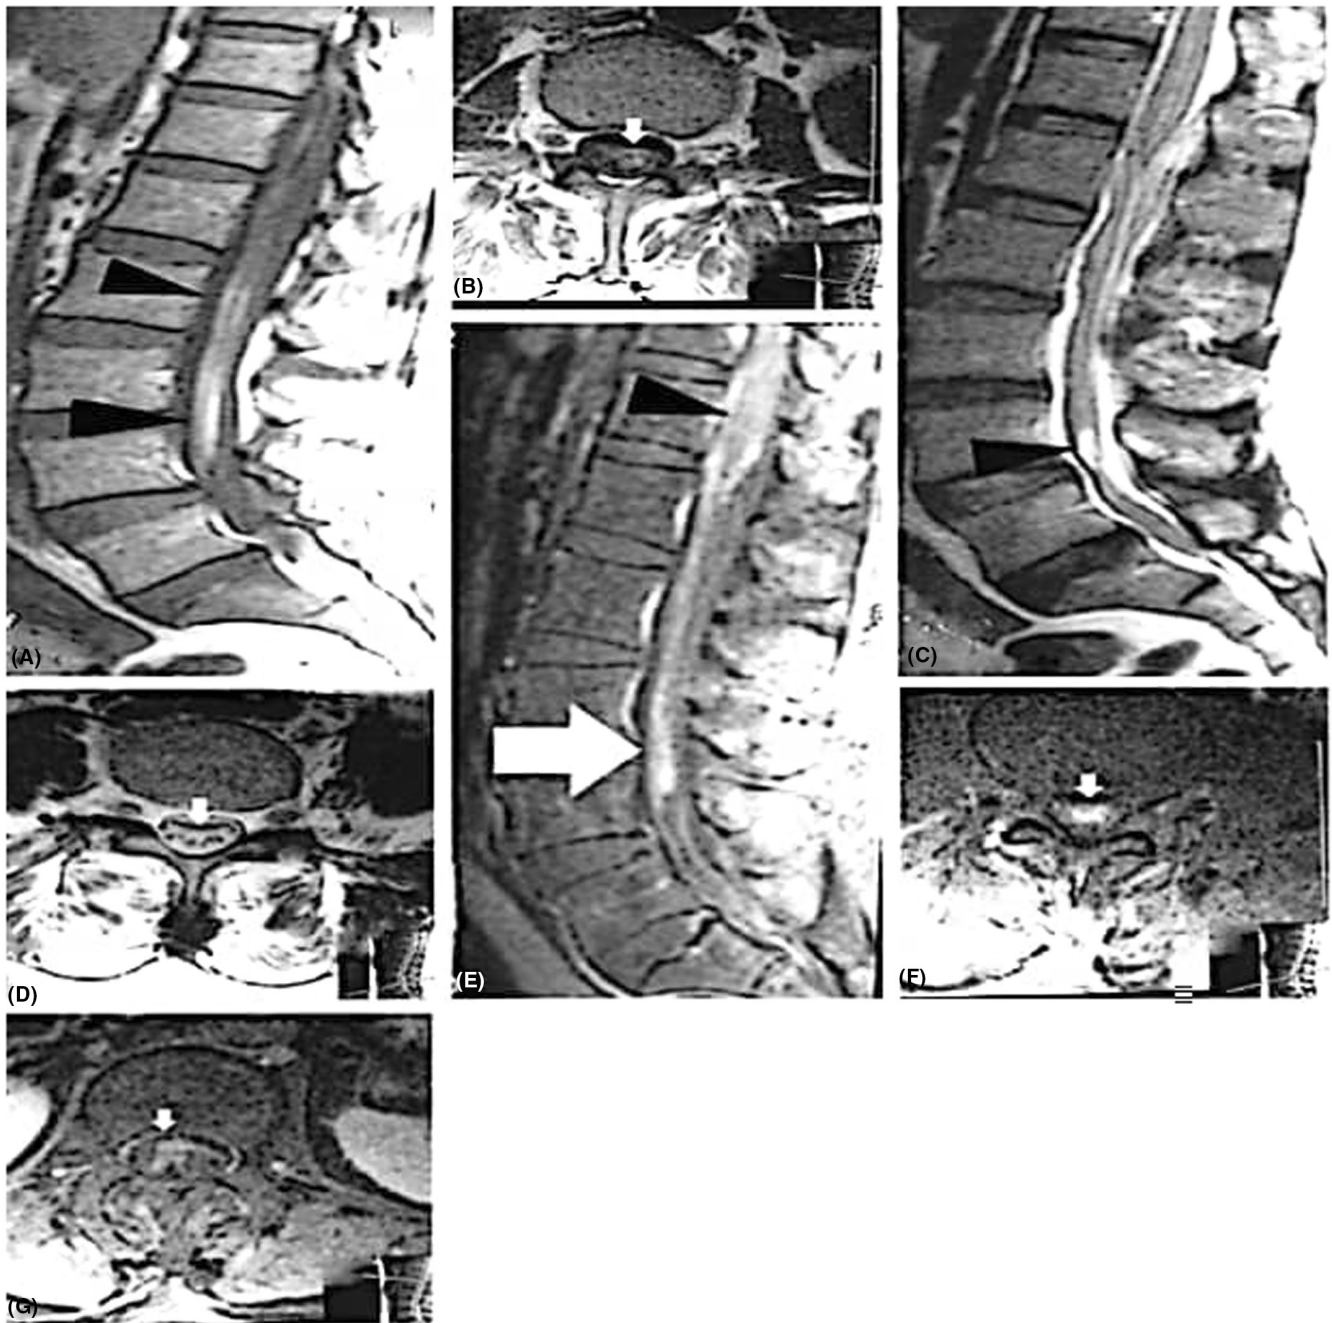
Magnetic resonance image shows hyperintensity and enhancement consistent with GBS.
